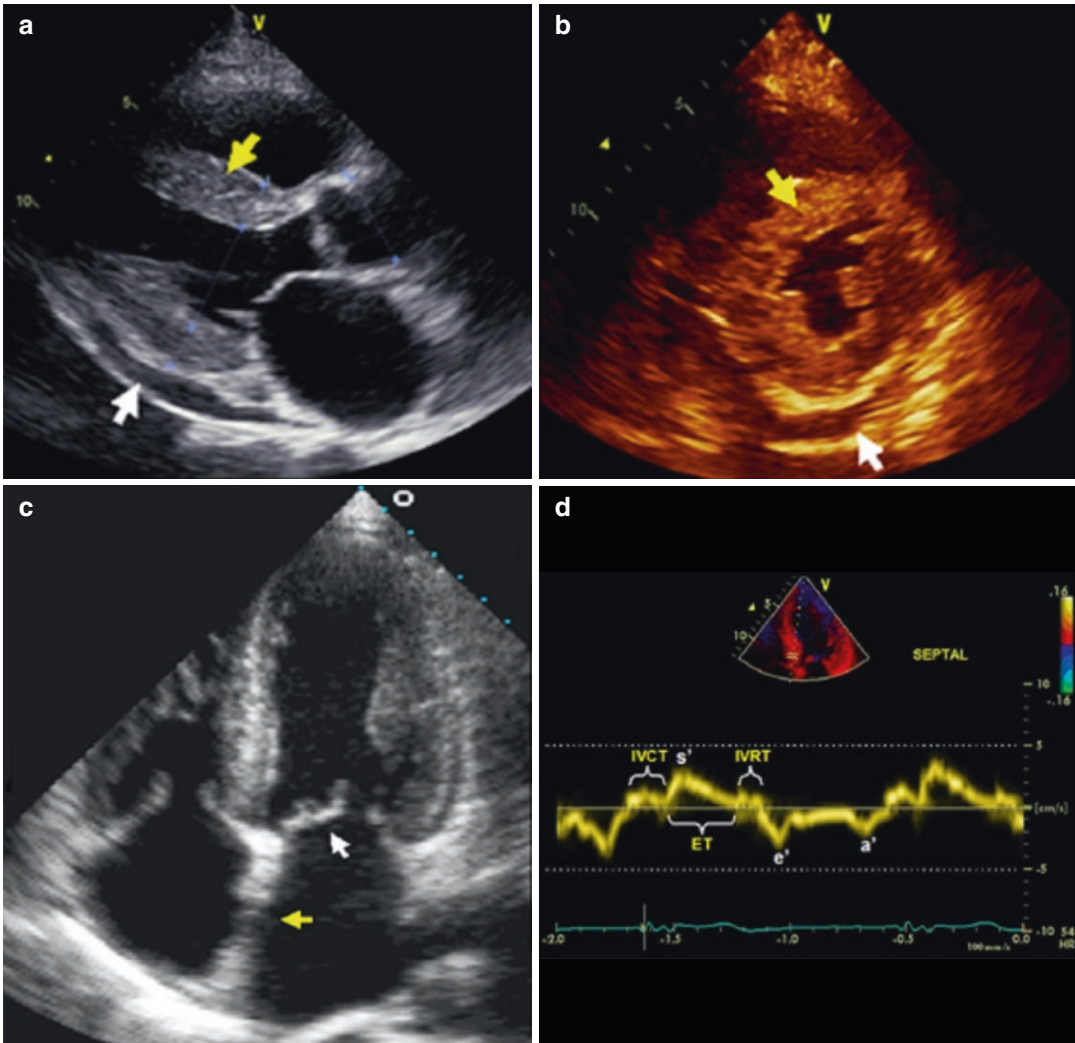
Characteristic appearance of cardiac amyloidosis on echocardiography. (a) (Parasternal long axis) and (b) (parasternal short axis) demonstrate increased LV wall thickness with a sparkling texture of the myocardium (yellow arrows) in a patient with primary (AL) cardiac amyloidosis. A small pericardial effusion is present (white arrows). (c) (Apical four-chamber view) demonstrates increased biventricular wall thickness, biatrial enlargement, and increased thickening of the interatrial septum (yellow arrow) and mitral valve leaflets (white arrow) in a
